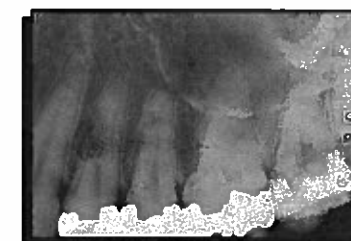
Case 4, two weeks after restoration with "IRM" tooth 27 became acutely painful. The radiograph shows the extreme depth of the restoration.
